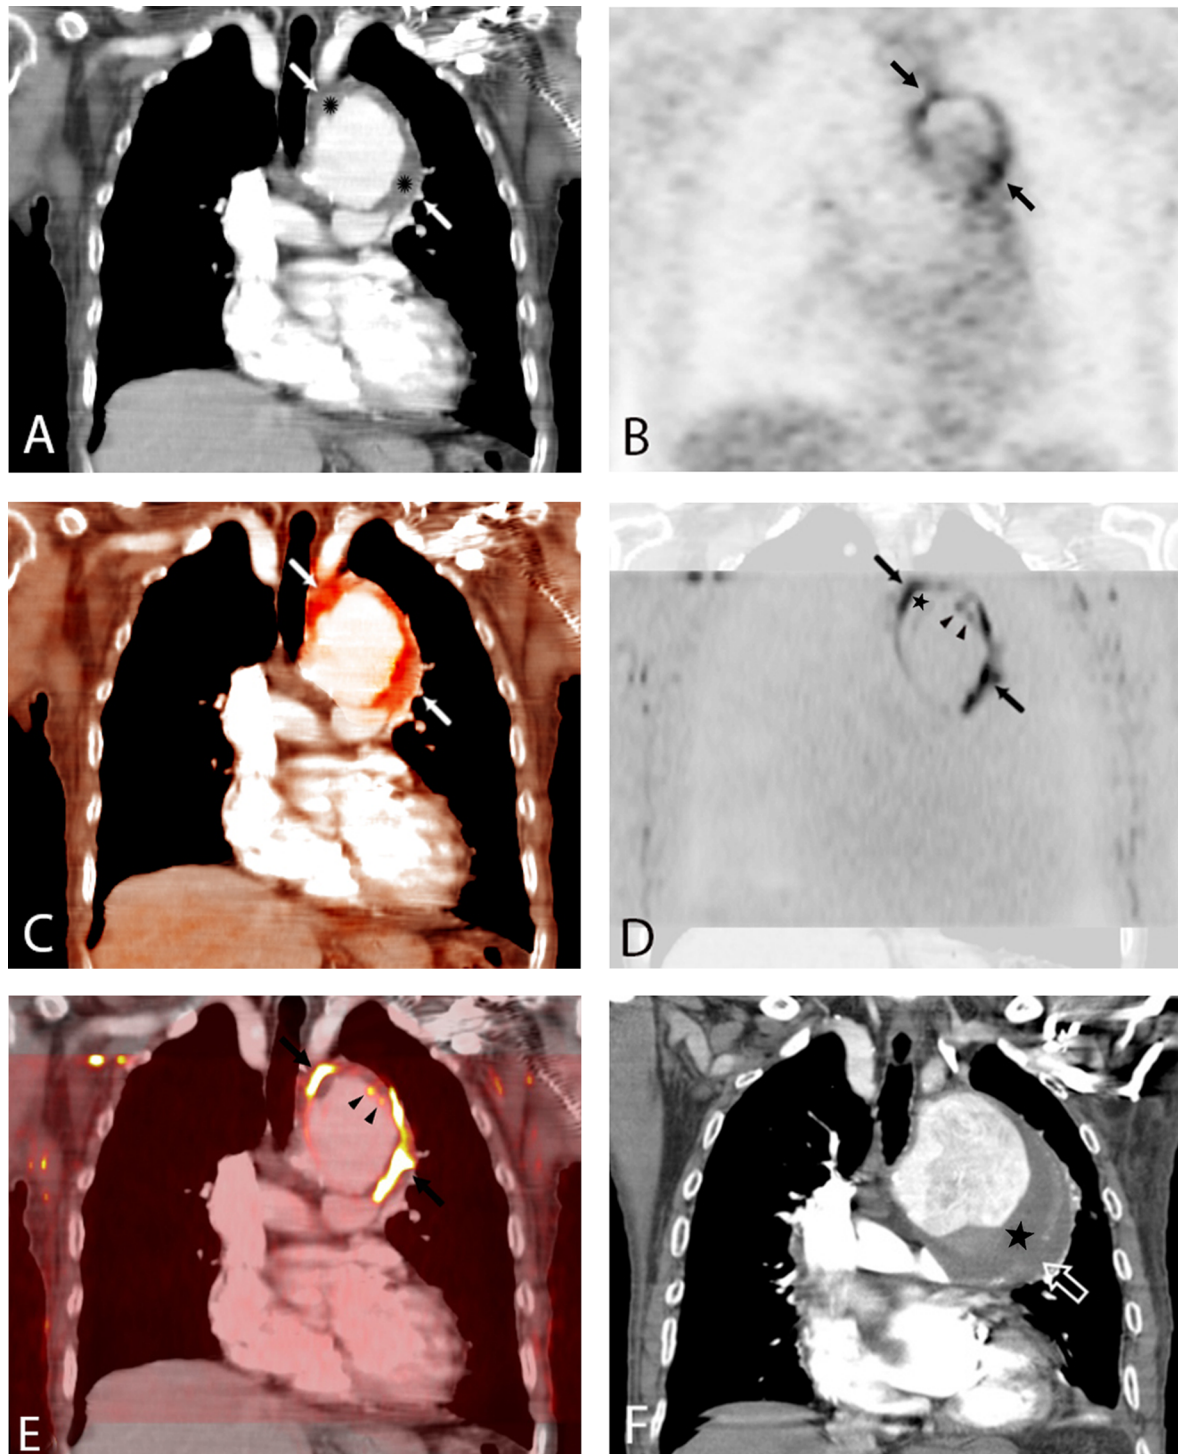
A. Coronal reformatted contrast-enhanced computed tomography (CT) of the chest demonstrates a large aortic arch aneurysm, with an intraluminal thrombus (ILT) (stars). ^{18}F -Fluorodeoxyglucose positron emission tomography (FDG-PET) (B) and color intensity maps fused with CT (C) showed FDG uptake on the aneurysm wall (arrows, D). E. Coronal reformats of transverse diffusion-weighted magnetic resonance images with a diffusion factor value of 800 s/mm^2 were fused to CT images in a similar plane and showed restricted diffusion on the aneurysm wall (arrows), but differed from FDG-PET by increased signaling on the luminal surface of the ILT (arrowheads). The patient died three months later. F. Admission CT showed aortic enlargement and rupture on thrombus-covered aneurysm wall (open arrow).
